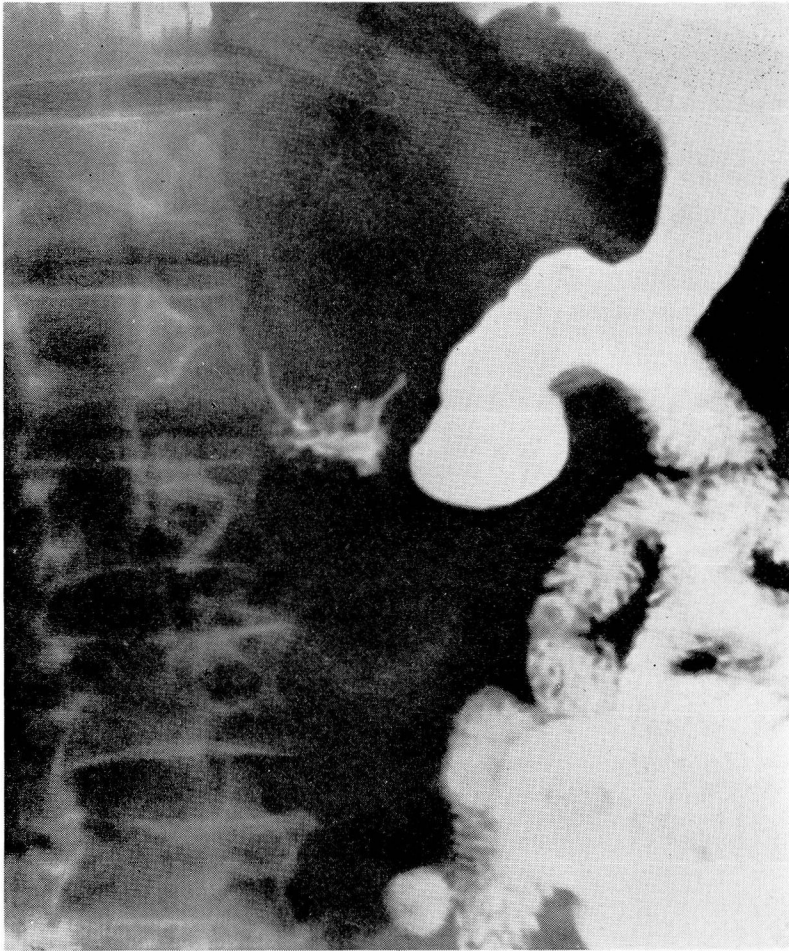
Roentgenogram of the stomach showing a constant narrow channel in the pars media with some rigidity of the walls and an obliteration of normal mucosal markings.
